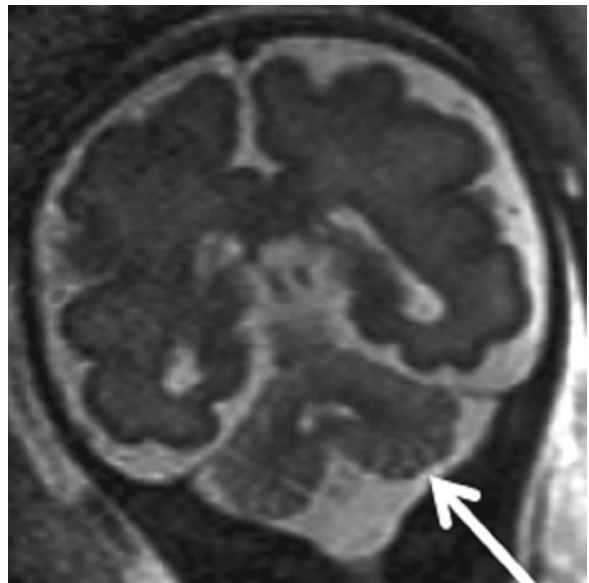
Coronal T2-weighted sequence of a fetus at 26+0 GW. The distal tips of the cerebellar foliae are focally hypointense on T2-weighted images, which could be due to a higher density of Purkinje cells in the periphery
